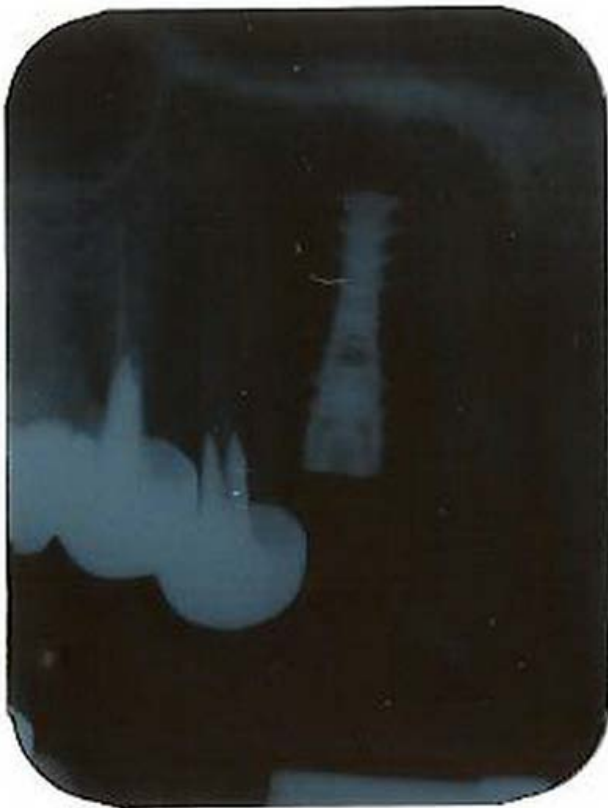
Radiographic view of the implant immediate after insertion
